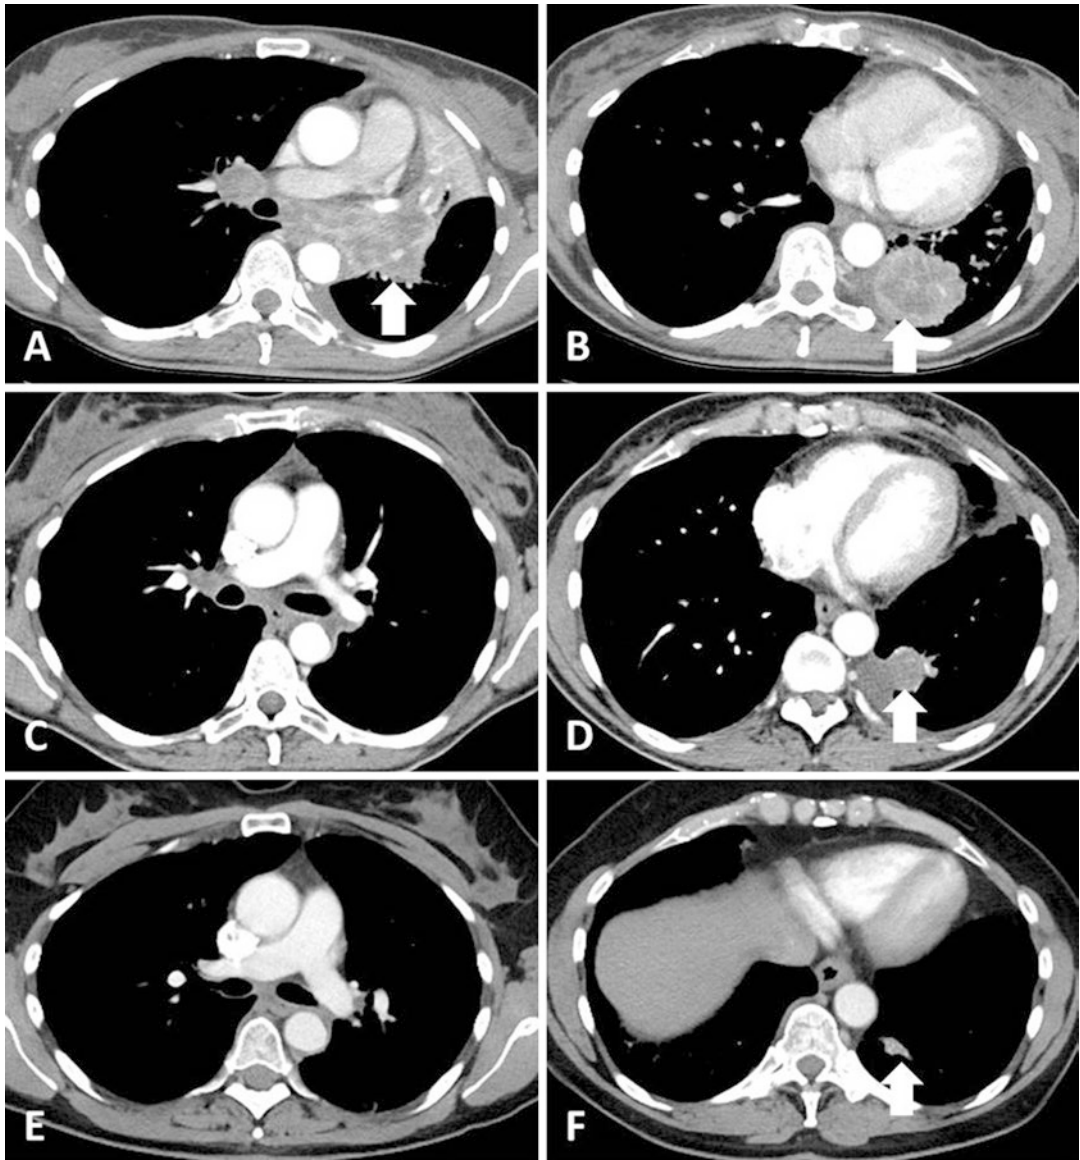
A 42-year-old woman with advanced NSCLC treated with nivolumab. (a, b) Baseline CT shows an irregular mass (arrow, a) with post-obstructive atelectasis in the left upper lobe involving the subcarinal lymph nodes, and a dominant lobulated mass in the left lower lobe (arrow, b). Enlarged right hilar node was also noted. (c, d) At 2 months of nivolumab therapy, marked response
